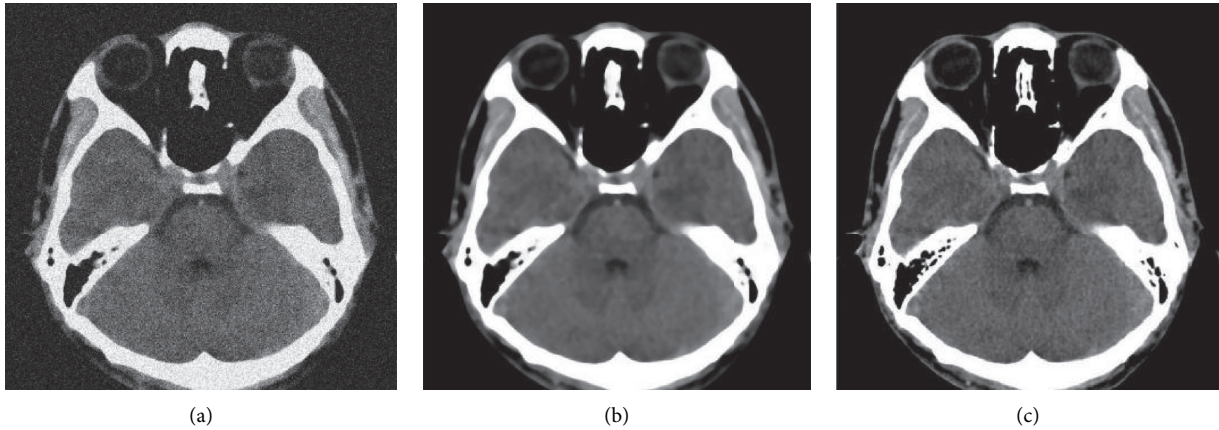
Visual comparison of head CT images optimized and processed in different ways. (a) original head CT image; (b) routine optimization of head CT image; (c) BPF algorithm optimization of head CT image.
